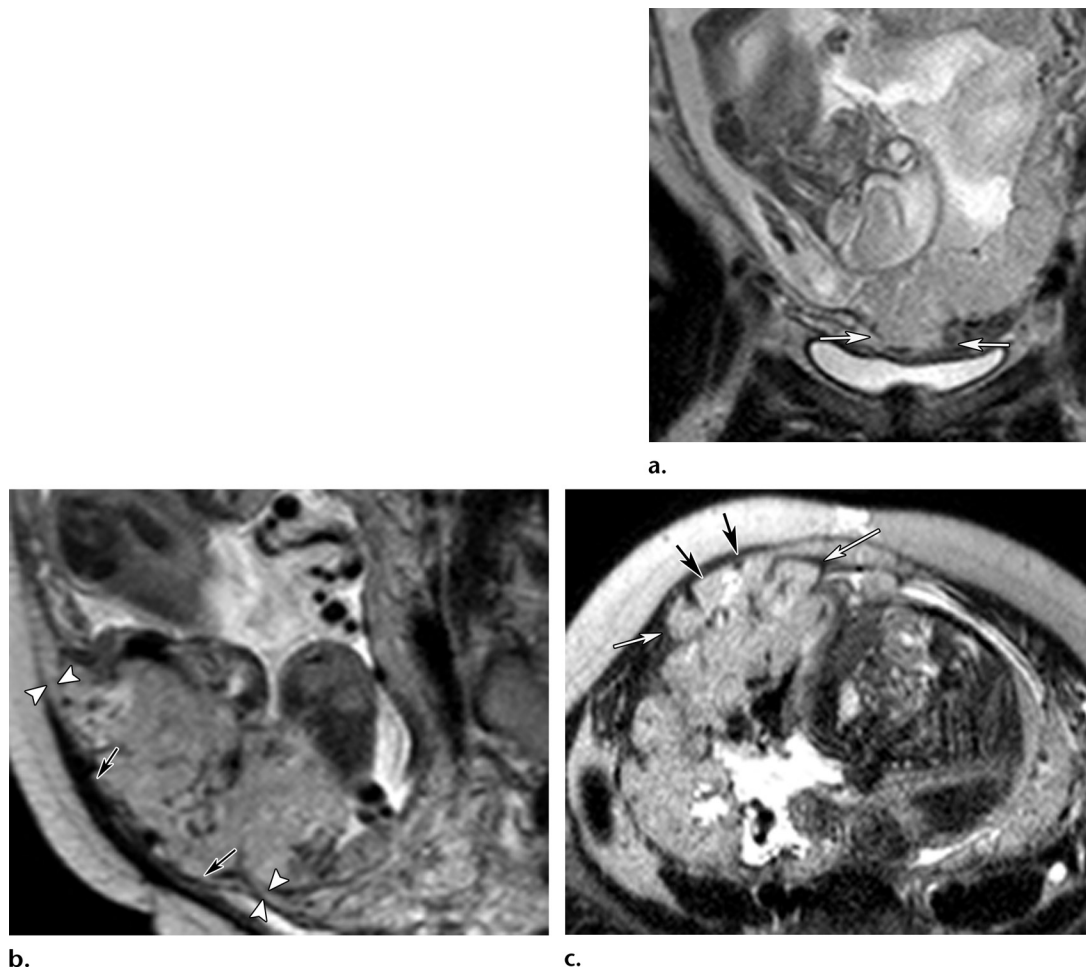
MR imaging features of MAP. (a) Placenta increta. Coronal T2-weighted image at 23 weeks gestation shows placenta previa with a focal bulge (arrows) at the lower aspect of the uterus, with discontinuity of the myometrium without bladder-serosa interruption. (b, c) Placenta percreta. Sagittal (b) and axial (c) T2-weighted images of another patient at 26 weeks gestation show a focal placental bulge (white arrows in c) at the right anterolateral aspect of the uterus, with discontinuity (black arrows) of the myometrium (arrowheads in b).
